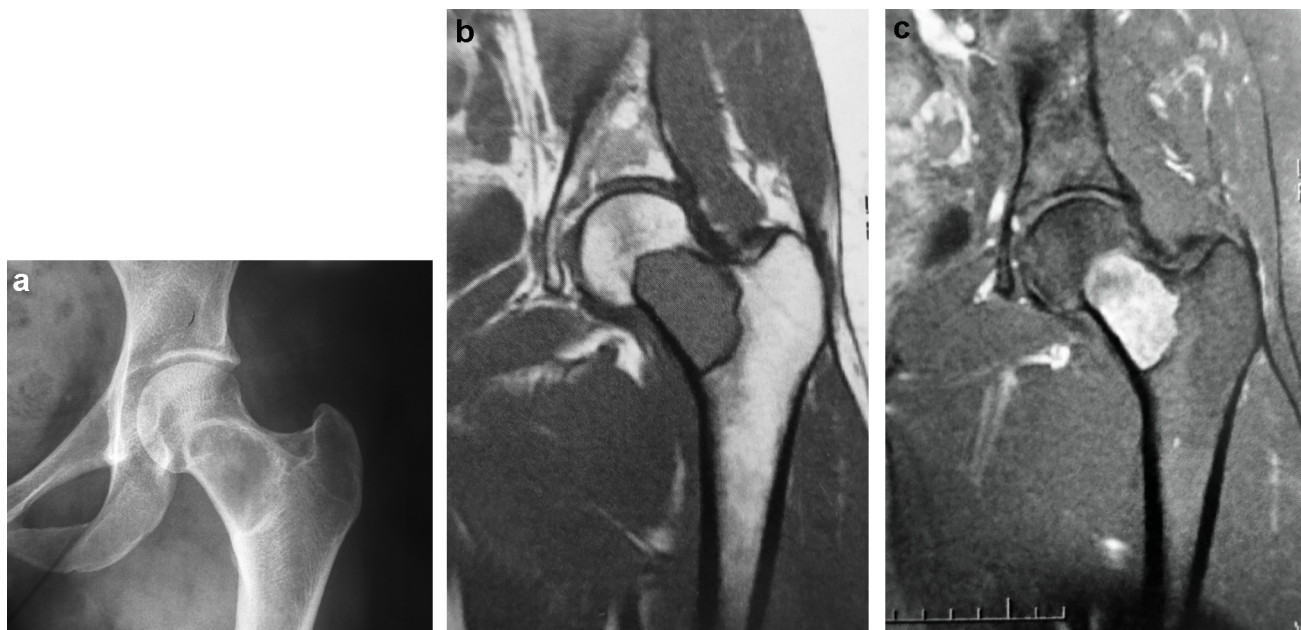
a. Radiographic aspect of UBC of the femoral neck. b and c. MRI coronal slice: intermediate aspect or hyposignal in T1 and intense hypersignal in T2-weighted sequences, homogeneous, indicating exclusively fluid content.
